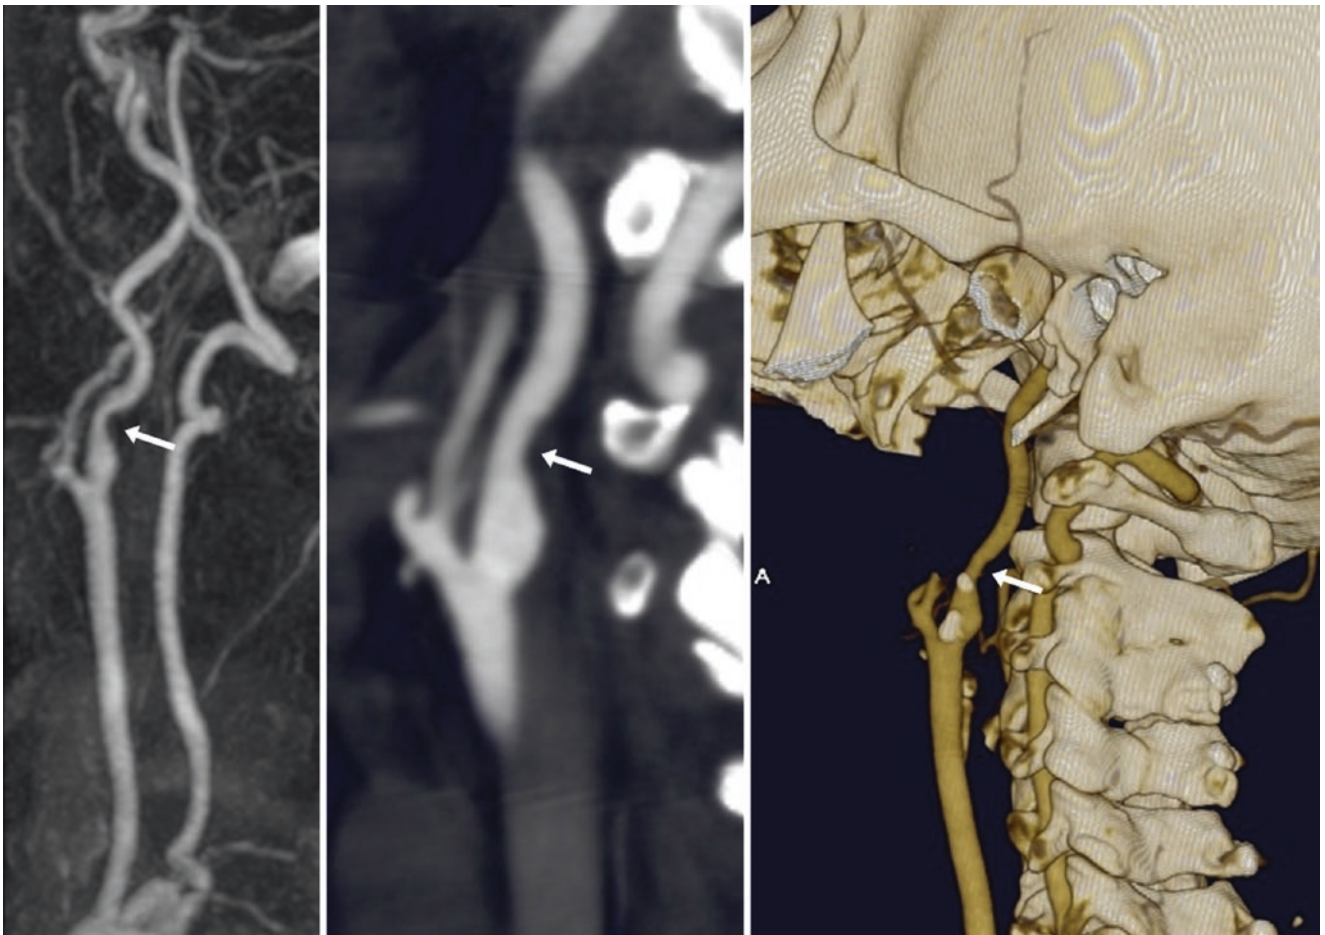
Pseudo-stenosis in this 63-year-old, a CEMRA lateral view of the right ICA (left) suggested a mild to moderate stenosis (arrows). However, on a CTA, a sagittal MPR (middle) and a 3D VR lateral view with the external carotid artery and its branches removed (right)
